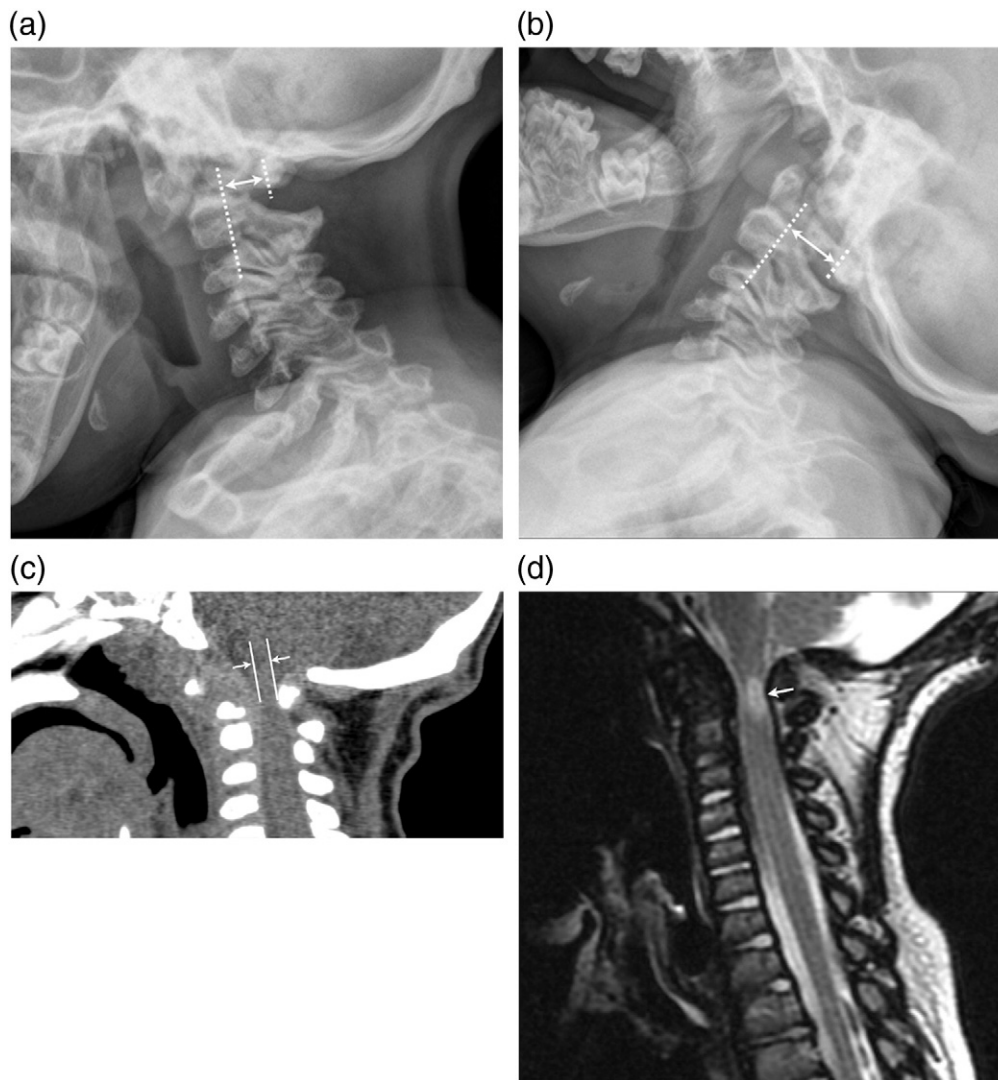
A 3-year-old MPS VI subject presented with clinical myelopathy and pre-surgical imaging findings of cervical instability, stenosis, and myelomalacia. Surgical decompression and stabilization was performed without complications. (a) and (b) Lateral flexion-extension radiographs. During flexion and extension, there is atlanto-axial instability with narrowing of the bony spinal canal from 17 mm during extension to 10 mm during flexion. Measurements are made at the spinal canal as shown rather than at the pre-dental space. (c) Cervical spine CT, soft tissue filter and window. There is dysplasia and delayed ossification of the cartilaginous odontoid process of C2, thickening of the cruciate ligament, and hypoplasia of the posterior arch of C1. All contribute to severe spinal stenosis with space available to the cord measured at 5 mm in the antero-posterior plane (double arrow). Radiographs have underestimated the severity of stenosis. (d) Cervical spine MRI. T2 TSE sagittal shows stenosis at C1, cervical cord compression, and a 4x10 mm focus of high cord signal indicating myelomalacia (arrow).
